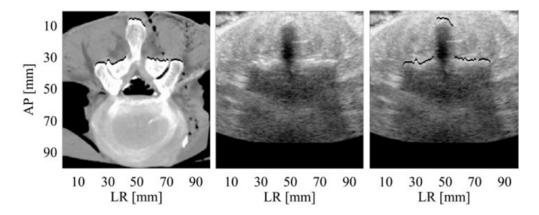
Registration of US/CT images of the human spine through feature extraction approaches. Brendel et. al 2002
